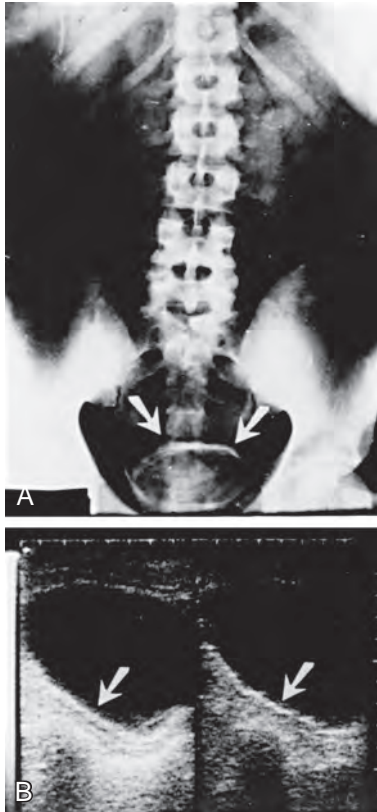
Bladder calcification in a 30-year-old Egyptian farmer. A, Plain x-ray film of the abdomen shows a rim of calcification surrounding the urinary bladder (arrows). B, Abdominal ultrasound study shows a bright line surrounding the bladder with a definite dark rim behind it (arrows). (A and B, Courtesy G. Thomas Strickland, MD. From Abdel-Wahab MF, Ramzy I, Esmat G, et al. Ultrasonography for detecting *Schistosoma haematobium* urinary tract complications: comparison with radiographic procedures. *J Urol* 1992;148:346.)
